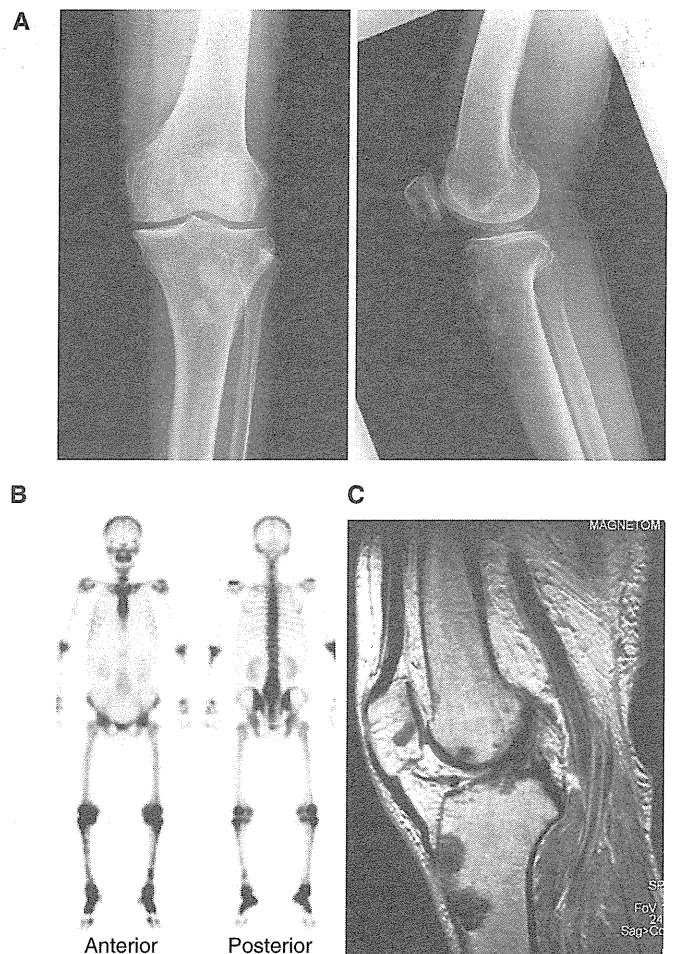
Skeletal imaging of the legs. (A) X-ray showed the presence of osteosclerotic lesions in the tibia. (B) Symmetrically increased osteoblastic activity primarily in the lower limbs was detected on bone scintigraphy. The diaphyses and metaphyses of the femurs and the tibiae were primarily affected, whereas the mid-diaphyses and epiphyses were spared. (C) MR imaging revealed bone lesions at the same positions as those shown in (A).
